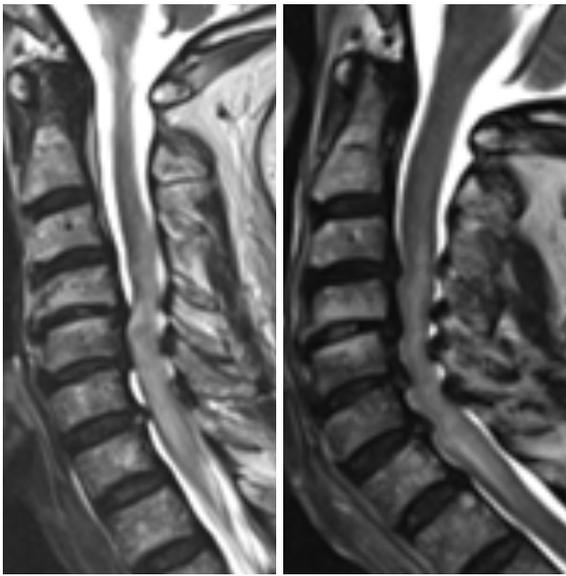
Case #12: static MRI was classified as C4-C5 2ap, C5-C6 2ap, C6-C7 2ap. Extension MRI showed C3-C4 2ap, C4-C5 3ap, C5-C6 3ap, C6-C7 3ap, C7-T1 1a.
